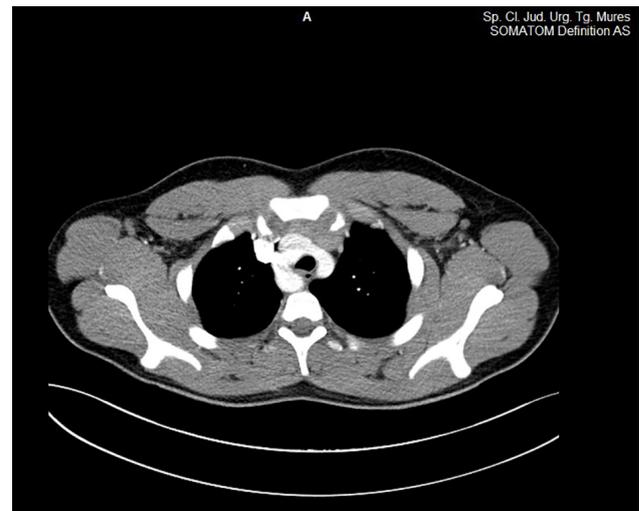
Thoracic CT angiography, axial section. DAA image.
